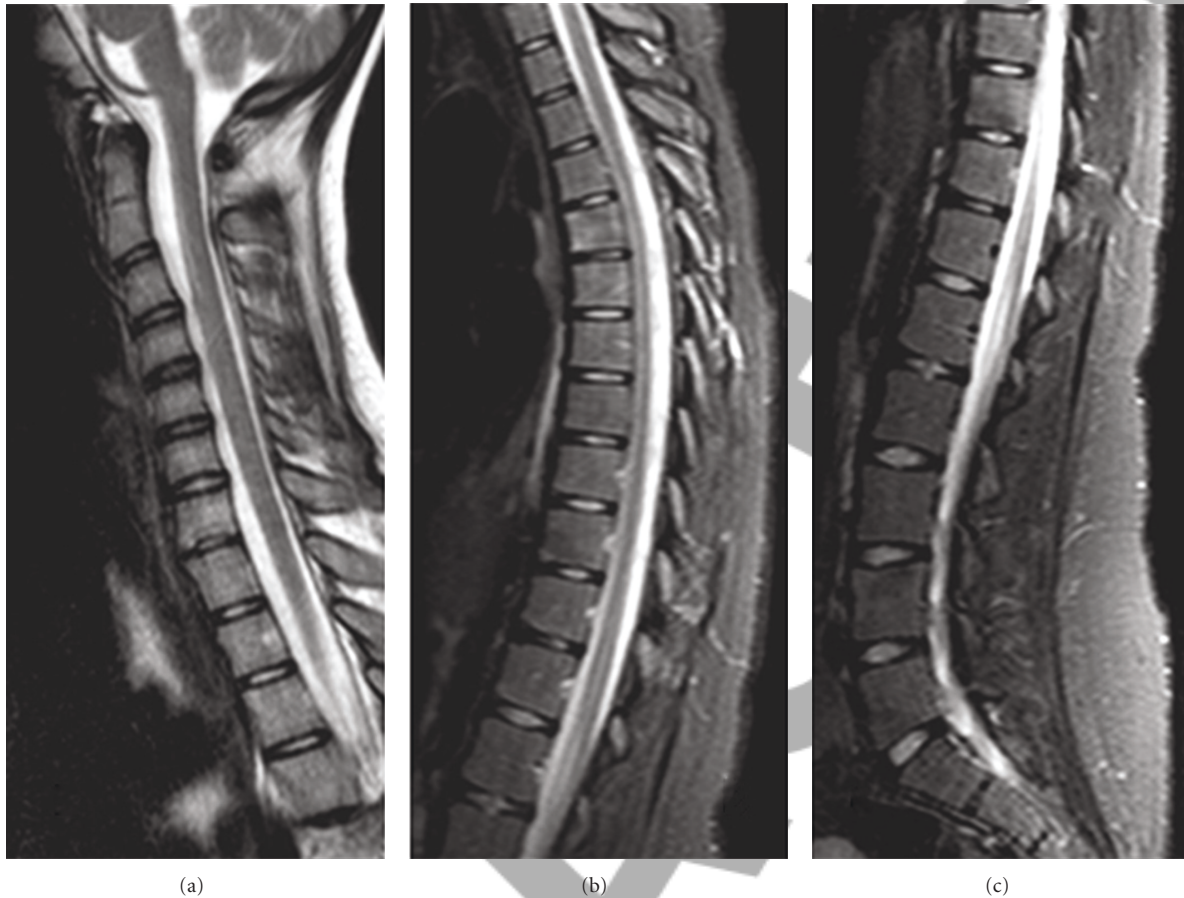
MRI of the spine one year from the disease presentation.
